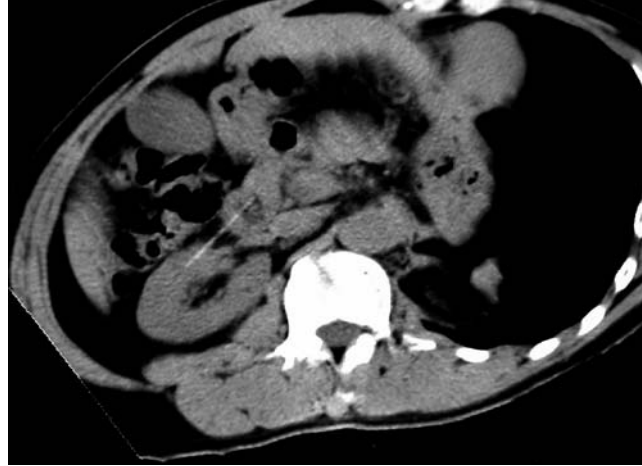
Abdominal computed tomography (CT) showed a hyperdense needle-shaped structure penetrating the duodenal wall and into the right kidney.
